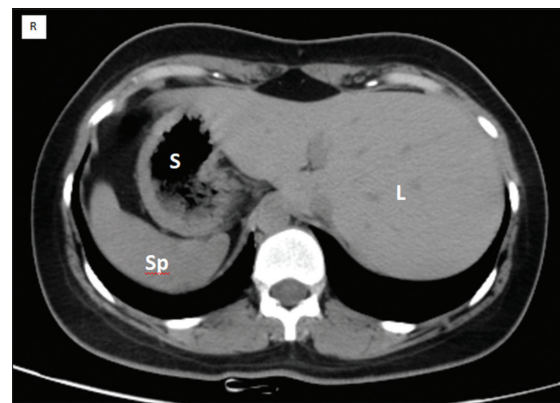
Axial computed tomography scan section at the abdominal level shows liver (L) on the left side and stomach (S) and spleen (Sp) on the right side. Aorta and inferior vena cava (IVC) also show total transposition, that is, the aorta is noted on the right and IVC on the left side, respectively. Neither asplenia nor polysplenia was noted
